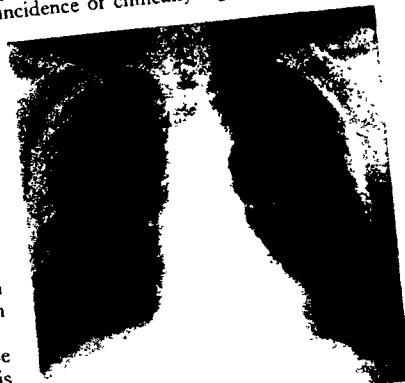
Case 196-3. Aged sixty-eight. Began working at age of sixteen. Farmer twenty-three years; carpenter six months; talc mill laborer and repair man twenty-nine years. Complains of dyspnea. *Physical examination:* Chest expansion $1\frac{1}{2}$ inches, respiration 24, râles both bases. *Roentgen examination:* Shows a diffuse, finely nodular fibrosis throughout both lungs. There is emphysema at the left base. There is apparent thickening of the pleura at the right base with several horizontal shadows in this region. There is also an area of increased density extending from the second to the third interspace on the right, and shadows at both apices suggesting possible reinfection tuberculosis.
